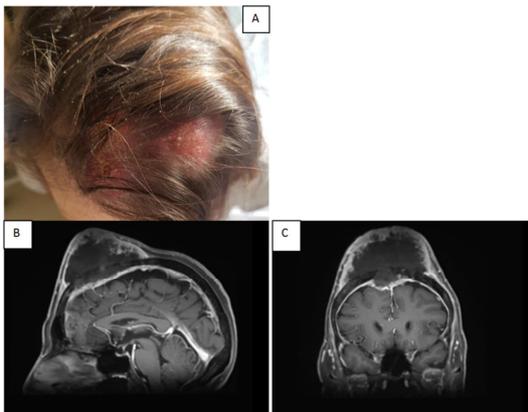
Dermatological aspect (A) and cerebral MRI with injection of gadolinium, sagittal (A) and coronal (B).
